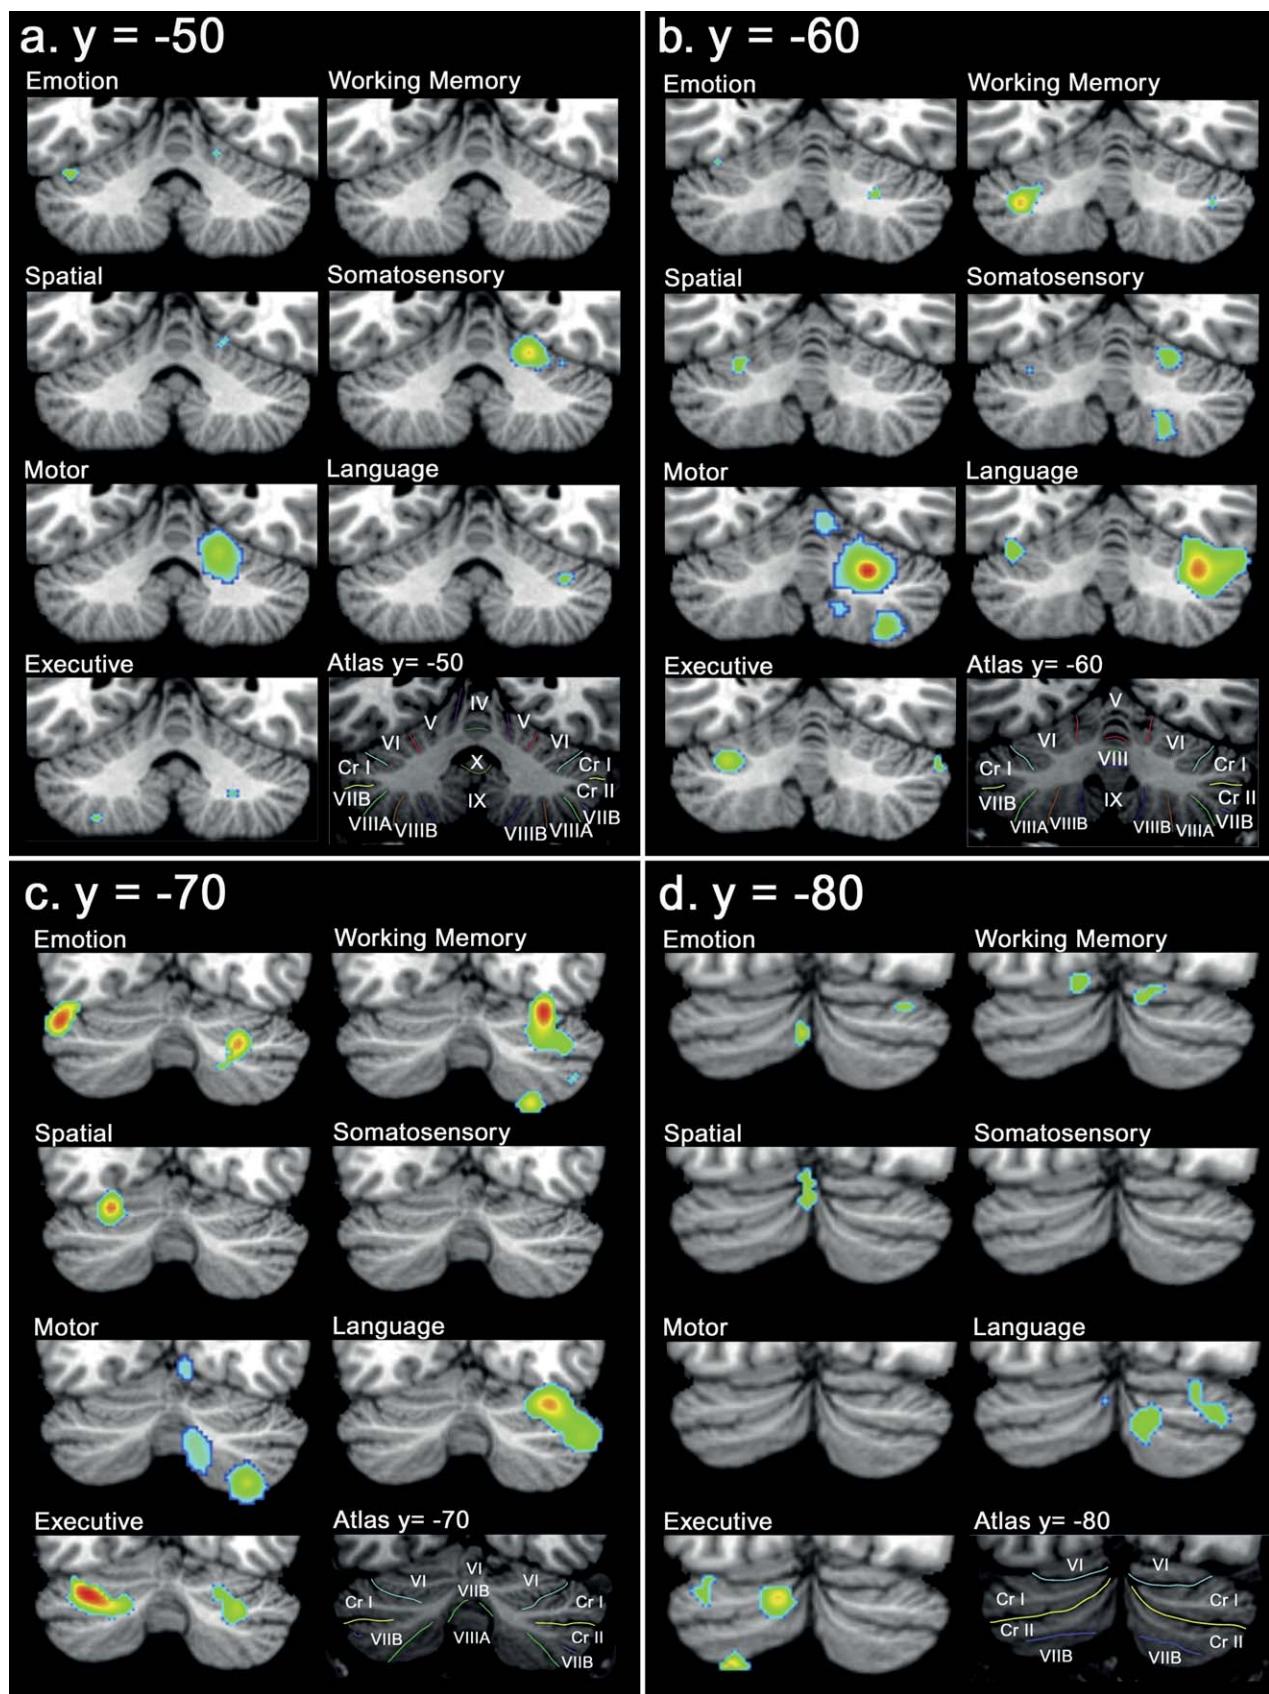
ALE activation maps for each domain at (a) $y = -50$, (b) $y = -60$, (c) $y = -70$ and (d) $y = -80$ mapped onto representative coronal sections of the Colin27 brain (left cerebellar hemisphere is shown on the left). For each coronal level, at the bottom right are corresponding coronal sections from the MRI Atlas (Schmahmann et al., 2000) with the cerebellar fissures and lobules demarcated and labeled.
